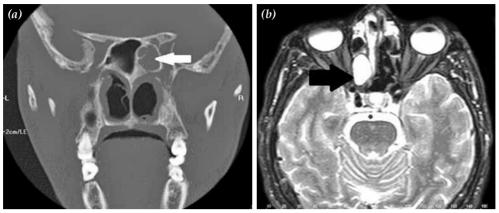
(a) Computed tomography of the paranasal sinuses in axial section shows a lesion with soft tissue density in the right posterior ethmoid sinus (white arrow). (b) T₂-weighted magnetic resonance imaging of paranasal sinuses shows hiperintensity in the right posterior ethmoid cell (black arrow).
